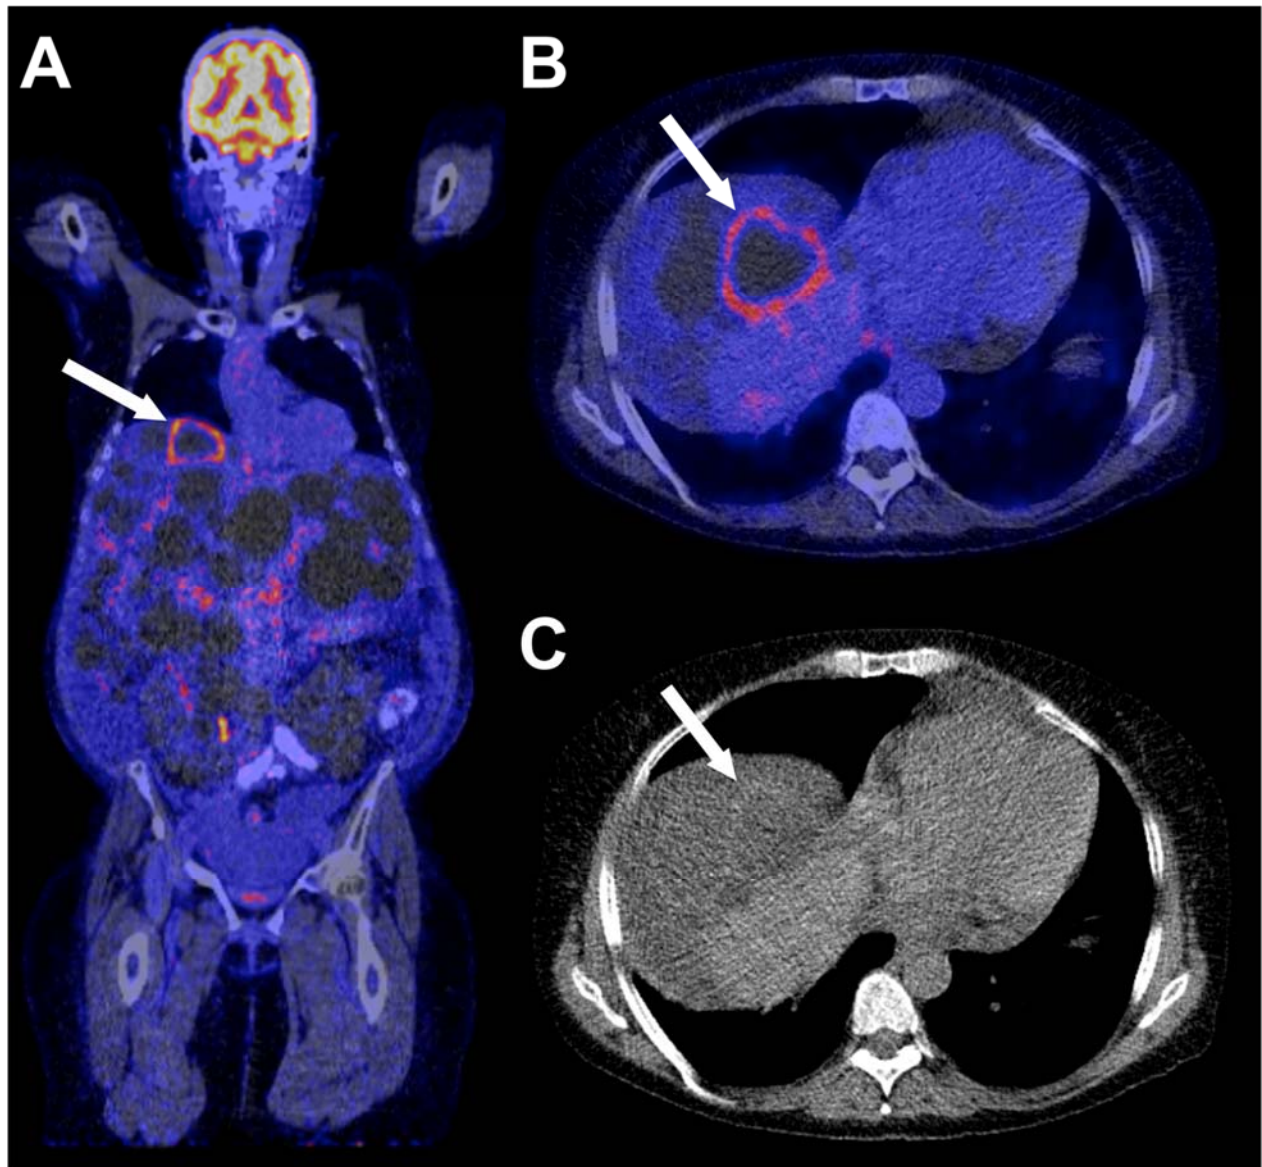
A 56-year-old woman with ADPKD in whom FDG-PET/CT was positive for hepatic cyst infection. Coronal (A) and axial (B) fused FDG-PET/CT show an FDG-avid cyst wall in liver segment 8 (arrows), indicative of infection. Axial CT at the same level shows the cyst (arrow), but is otherwise unremarkable. The criteria for cyst infection according to Sallée et al. (5,10-13) were also met in this patient.
